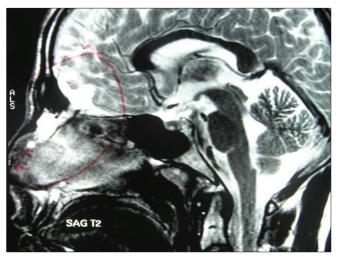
Sagittal T2 MRI image showing sinus tract upto the nasal tip
